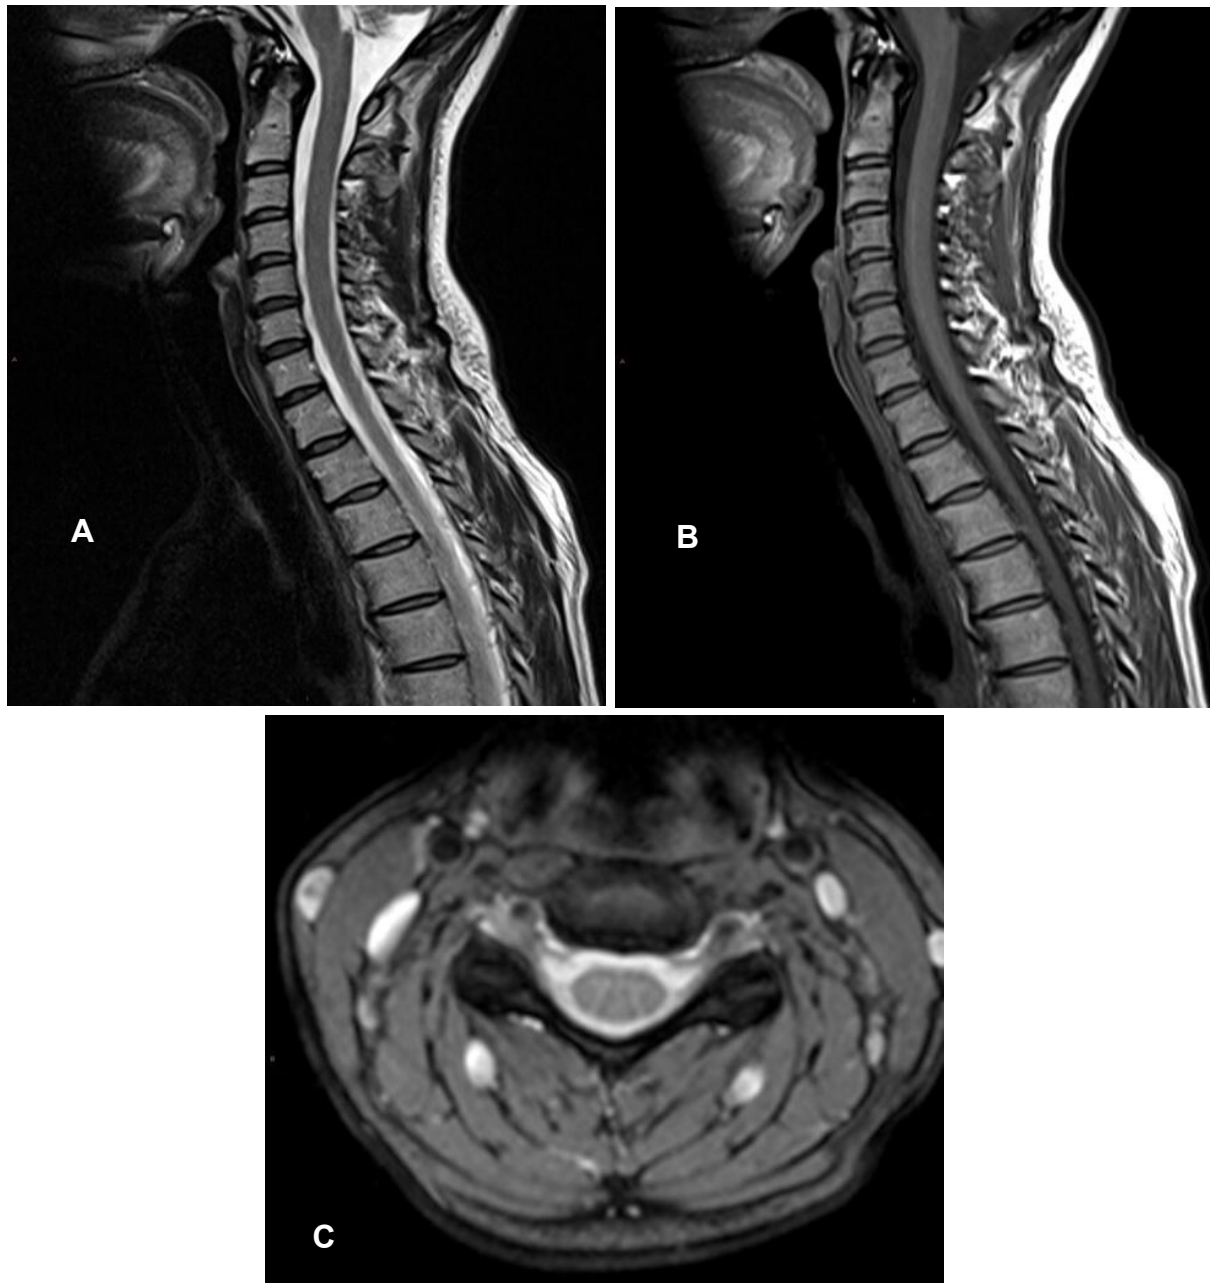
MRI demonstrating a typical clinical acquisition of a cervical spine. These views are typically orientated to the discs rather than the neuroforamina.
